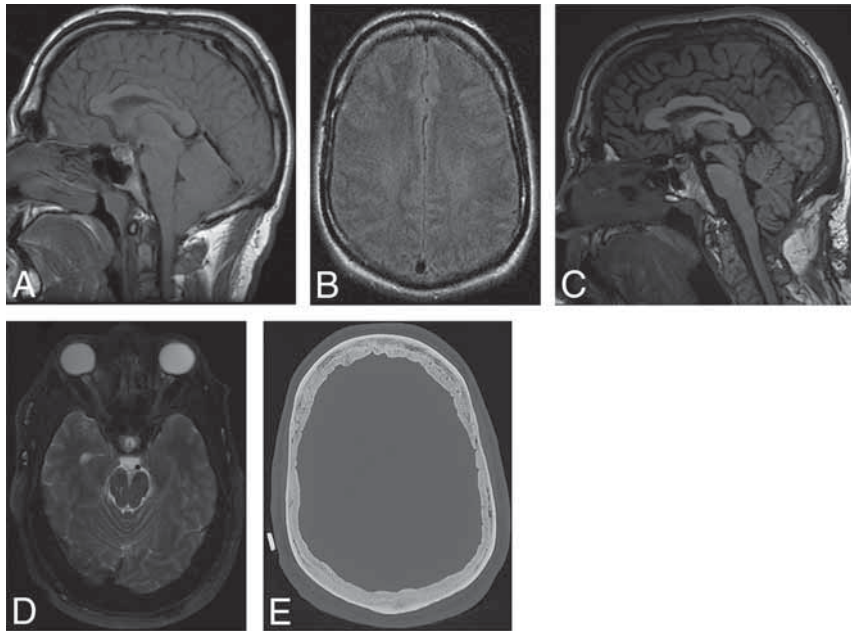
A 53-year-old man who developed refractory papilledema and rebound intracranial hypertension following repair of a CSF-venous fistula at T8–T9 at 51 years of age. Rebound intracranial hypertension symptoms began 3 weeks following treatment. Sagittal T1-weighted (A) and axial FLAIR (B) MR images at 29 years of age demonstrate brain sag with normal baseline qualitative calvarial thickness, respectively. Sagittal T1-weighted (C) and axial T2-weighted (D) MR images at 51 years of age demonstrate improvement in brain sag with new posterior globe flattening indicative of papilledema, respectively. E, Preoperative stereotactic CT image before ventriculoperitoneal shunt placement demonstrates new layered calvarial hyperostosis.
